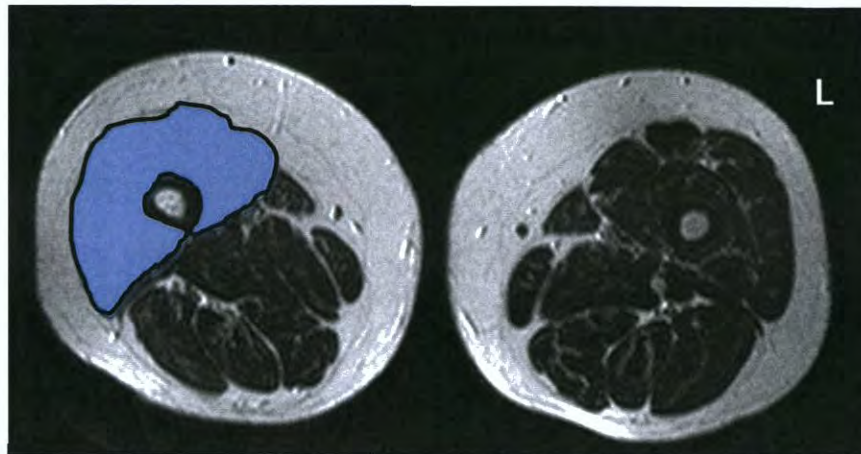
Determination of quadriceps femoris CSA from MRI scans
